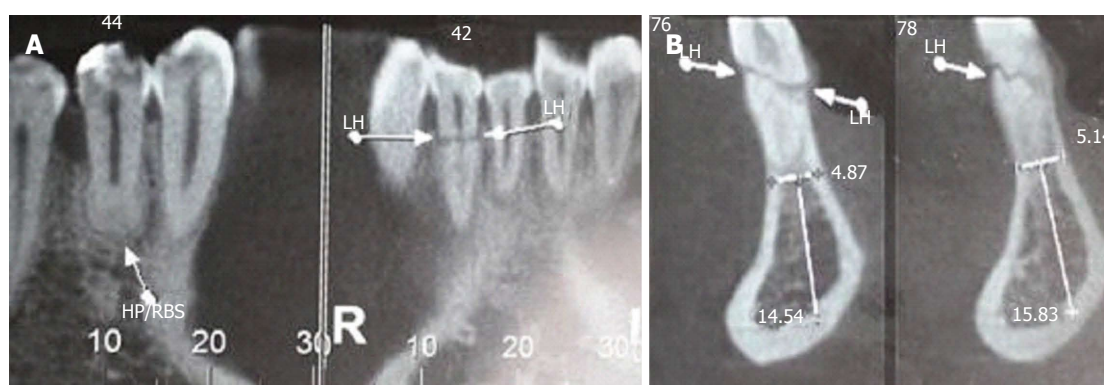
Cone beam tomography images. A: Cone beam computed tomography (CT) shows apex remodeling and root canal apical third obliteration of teeth 44 and 43, as well as fracture line in tooth 42; B: Cone beam CT shows oblique fracture line along the middle third of tooth 42. LH: Horizontal line.
